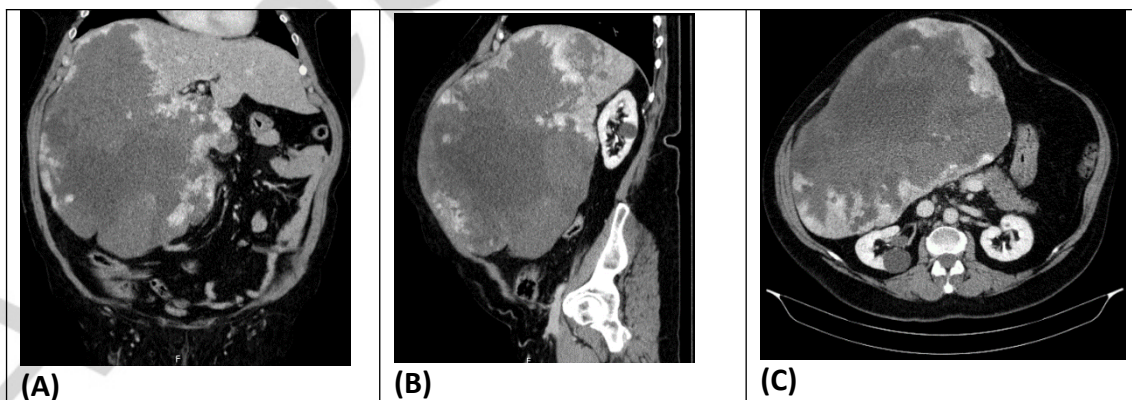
Image A - Contrast-enhanced coronal computed tomography scan demonstrating the huge size of the hemangioma which occupies the entire right lobe. Image B - Contrast-enhanced sagittal computed tomography scan demonstrating the significant mass
